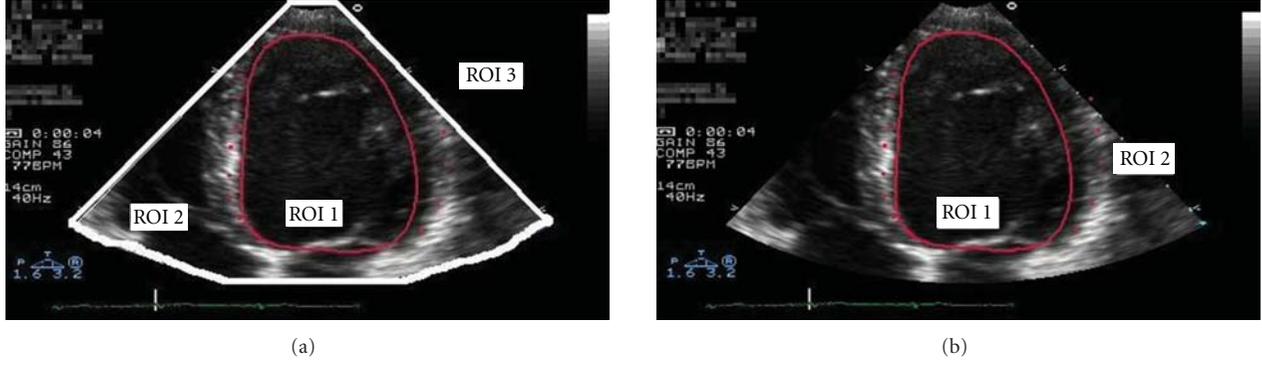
(a) Cardiac ultrasound image with ROIs (manually selected) highlighted. Three regions of interest, (b) Cardiac ultrasound image with ROIs highlighted. Two regions of interest.
